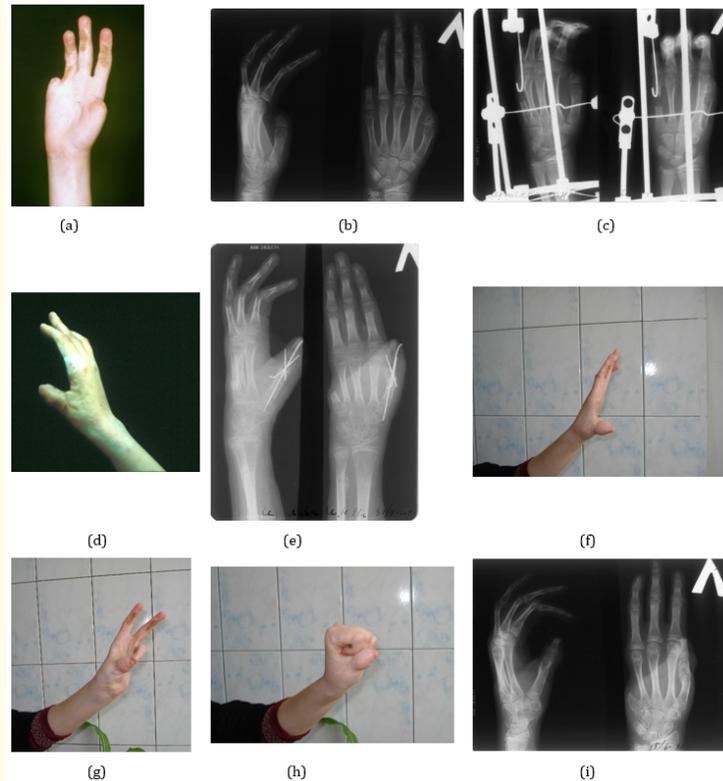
Patient I.C., female, 11 y.o. Hand deformity resulting from a burn: a - Appearance of the hand before surgery; b - X-rays before surgery; c - X-rays after the second stage of the surgery, osteotomy performed on the fifth metacarpal, wire with a hooked base inserted intramedullary through the stump and the distal metacarpal segment for distraction, the other end of the wire attached to the Ilizarov apparatus, bony fragments partially set apart; d - Appearance of the hand after transferring the segment onto the thumb stump; e - X-rays after thumb reconstruction; f - Treatment outcome at 3 year follow-up, thumb abduction; g - Treatment outcome at 3 year follow-up, thumb opposition to the fourth finger achieved; h - Treatment outcome at 3 year follow-up, power grip; i - X-rays at 1 year follow-up.
